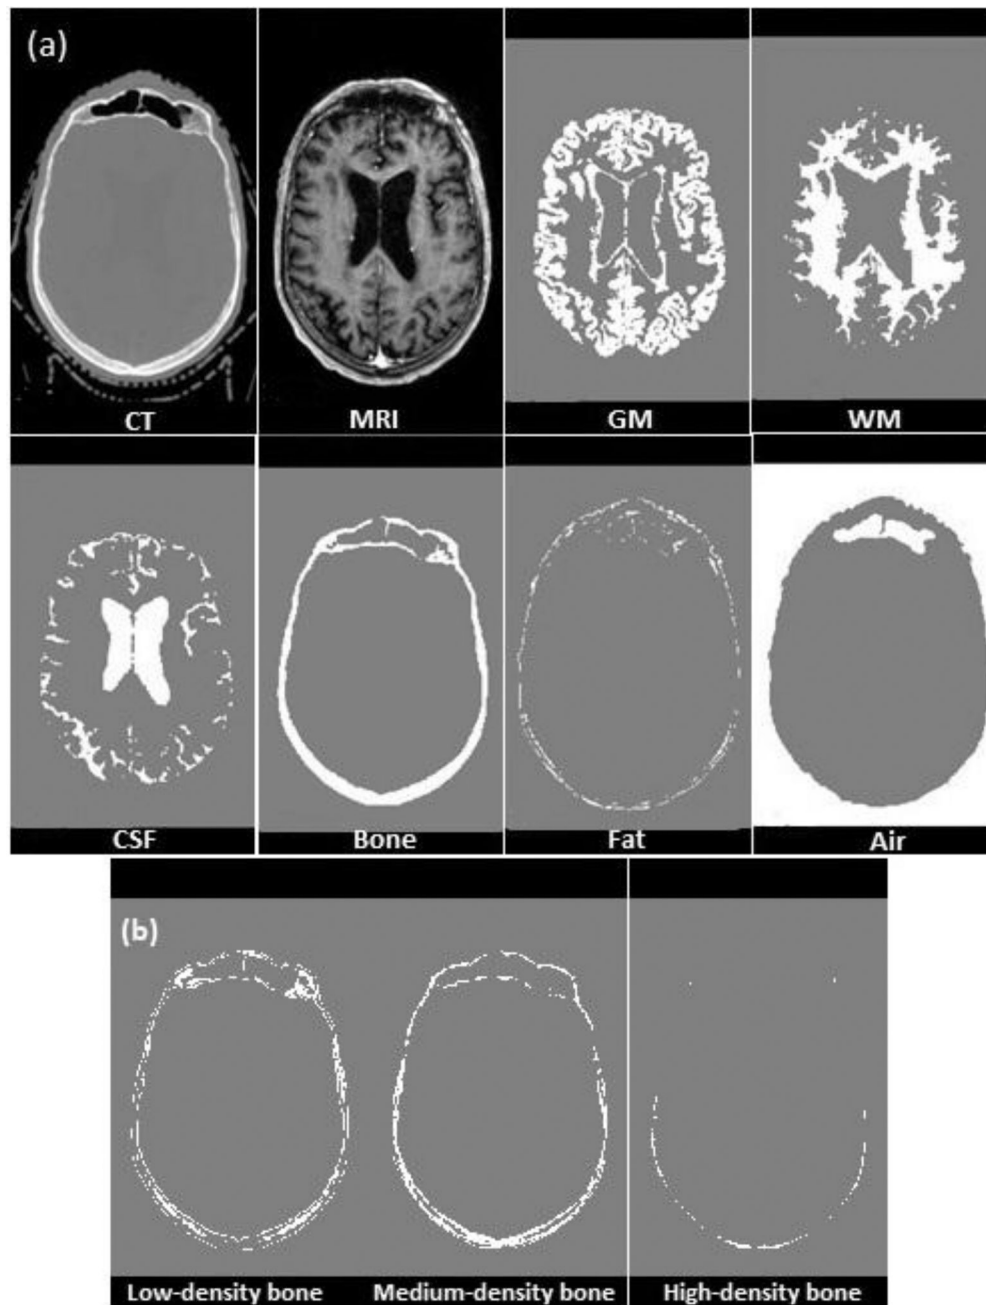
(a) Axial views of CT, MRI, segmentations of GM, WM, CSF, bone, fat, and air on the same slice for a typical patient in this study. (b) Axial view of bone segment which is further subdivided into low-, medium- and high-density bones.
